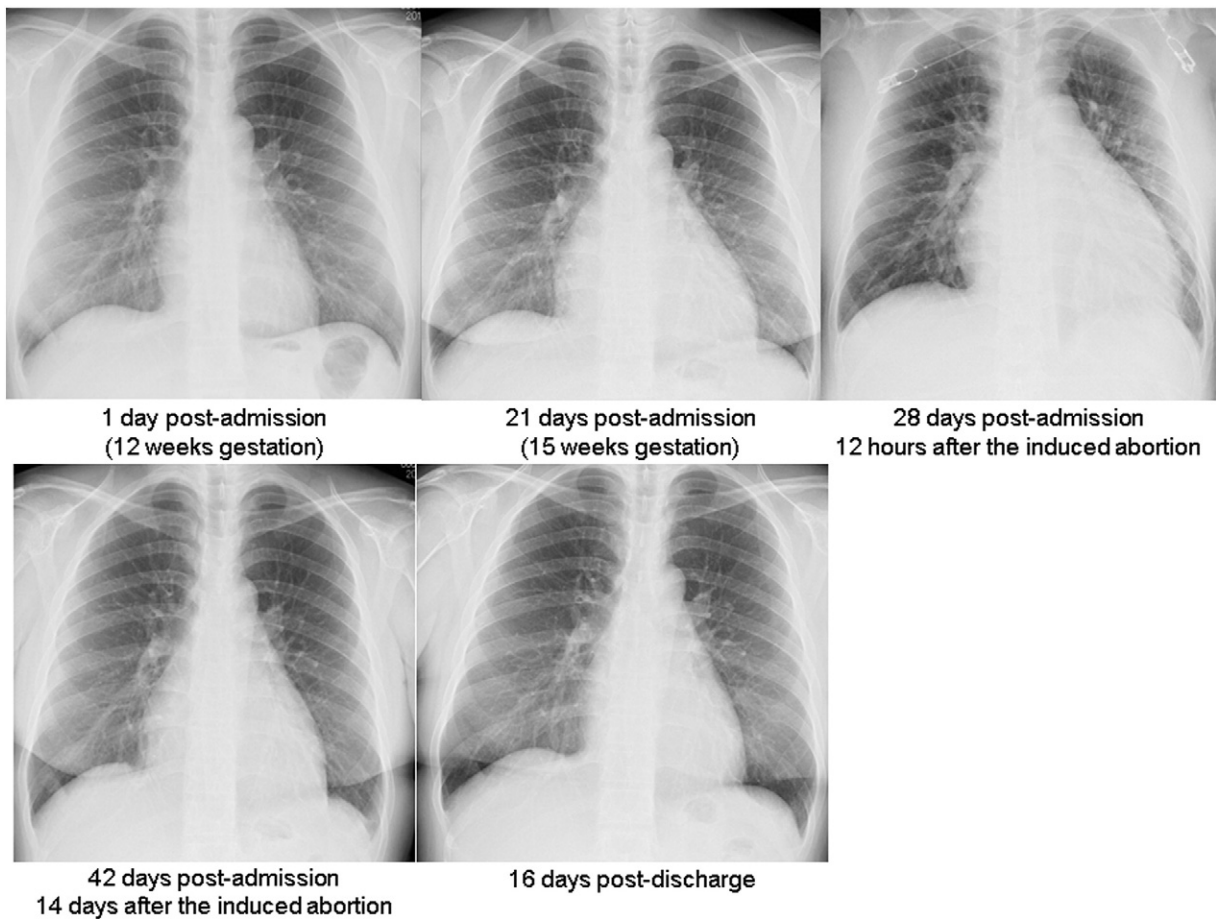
Series of chest X-rays (all posterior–anterior view on standing position except upper right X-ray, which is anterior–posterior view on supine position). Upper left; at 1 day after admission to our hospital (12 weeks gestation) the cardiac thoracic ratio (CTR) was 43.6%. Upper middle; at 21 days after admission (15 weeks gestation), the CTR was 53.6%. Upper right; at 28 days after admission, and at 12 h after the induced abortion, the CTR was 60.1% with worsened pulmonary vascular congestion. Lower left; at 42 days after the admission, and 14 days after the induced abortion, the CTR improved to 50.5%. Lower middle; at 16 days after discharge from our hospital, the CTR improved to 43.2%.
